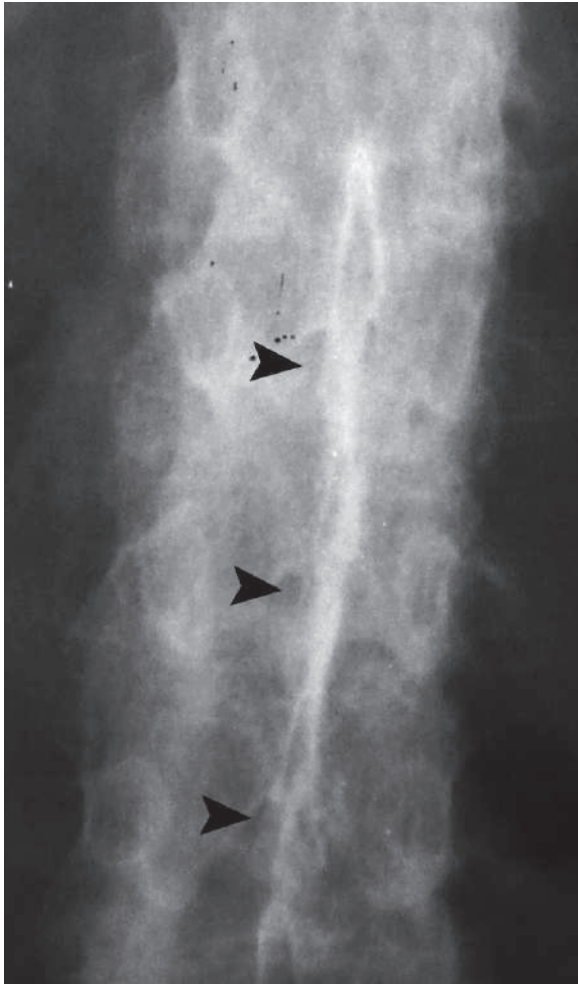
Anteroposterior plain radiograph of the thoracic vertebrae shows the dagger sign
